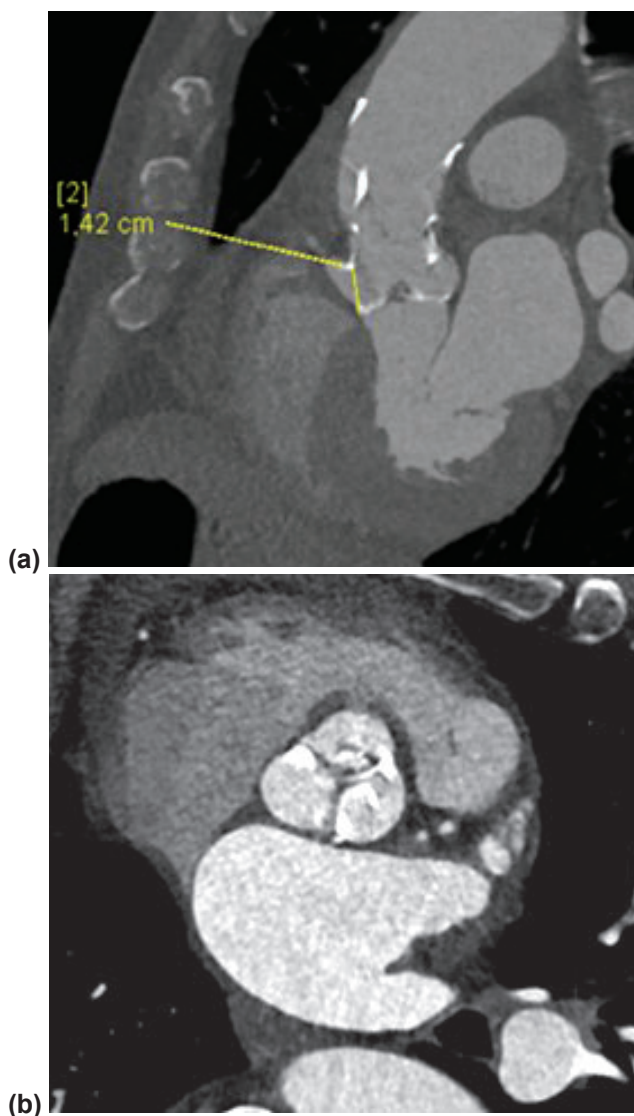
CT angiography of the ascending aorta one year post-implant (a) parasagittal plane demonstrating complete migration of the bioprosthetic valve at 1.42 cm from the native aortic ring. (b) transverse section at the level of the aortic cusps demonstrating massive calcifications
